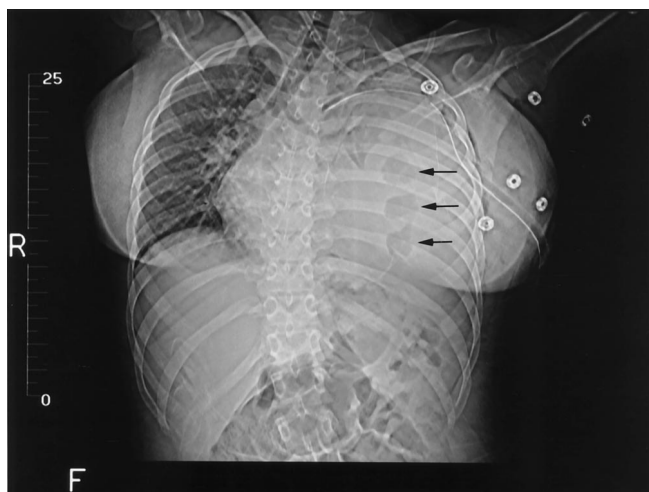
Supine computed tomography scout film of the chest showing almost complete left lung collapse, mediastinal shift, and tracheal deviation. A chest tube is in place. Note the presence of air within the segmental loops of bowel (arrows).
